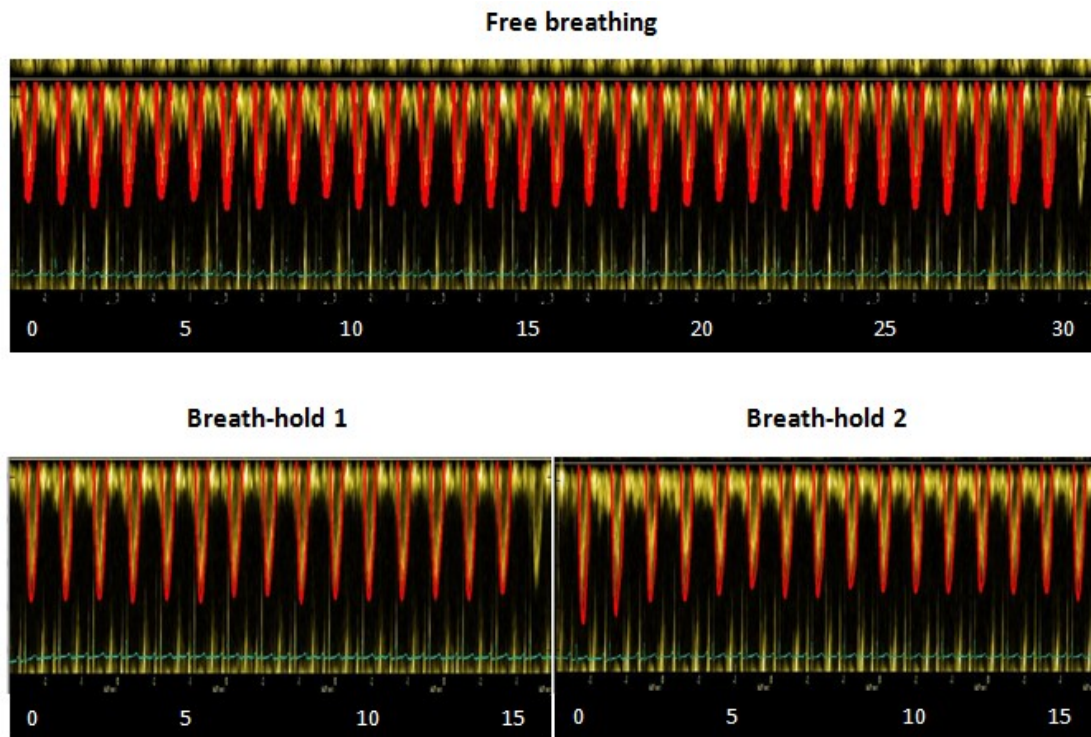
Prolonged pulsed wave Doppler recordings of LVOT velocity
